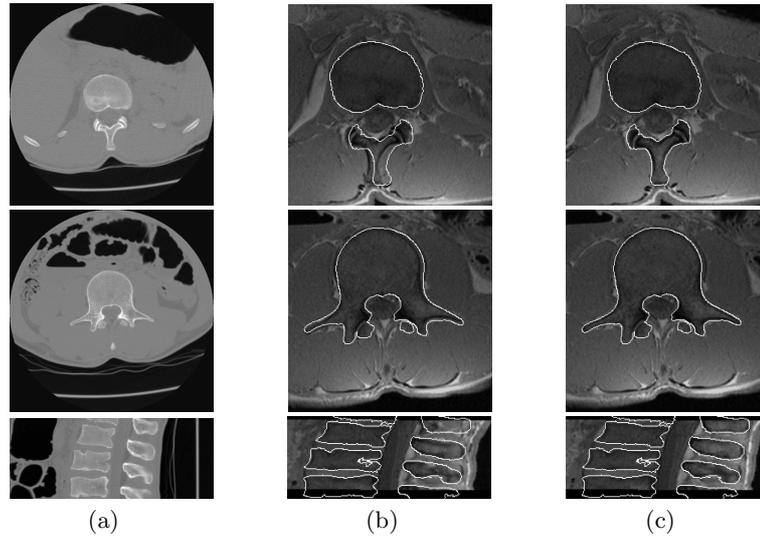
Result of a CT-MR spine registration. (a) Transversal and sagittal sections in the reference CT image. (b) The contours of the CT vertebrae overlaid on the corresponding sections in the floating MR image after the global rigid registration. (c) The contours of the CT vertebrae overlaid on the resulting MR sections after the piecewise registration procedure
